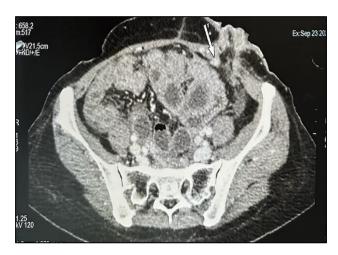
CT scan of nodule at the colostomy site marked with an arrow.
